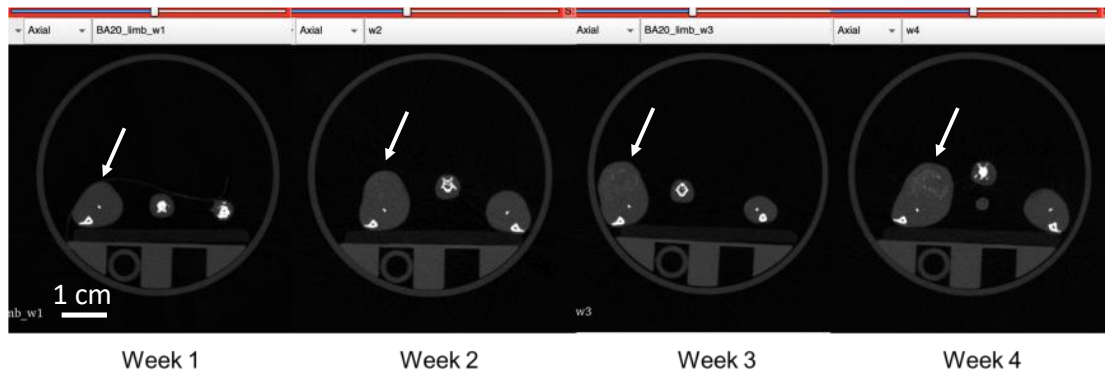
μ CT scan (axial view) showing the growth of the LM8 limb tumour (left limb) in 28 days. Resolution: 100 μ m. The white arrow indicates the tumour.
